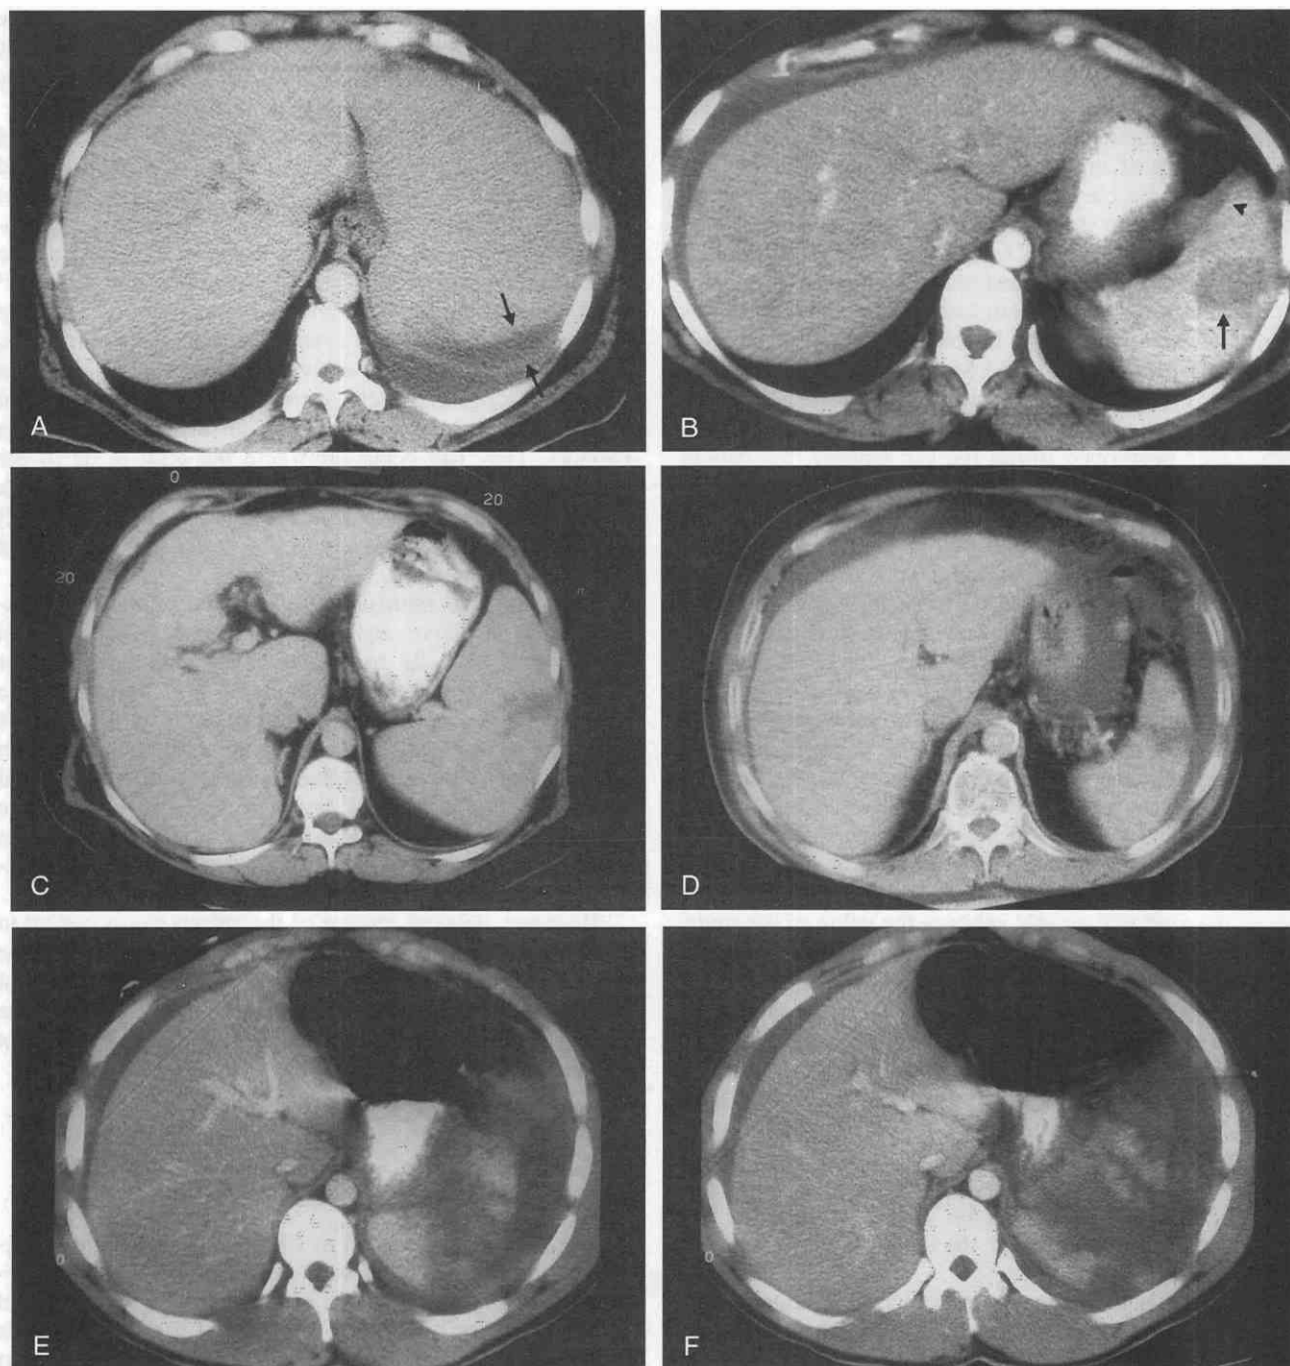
CT scans showing classification of trauma to the spleen. A, Grade I injury: A small subcapsular hematoma (arrows) can be seen in a patient with an enlarged spleen from chronic lymphocytic leukemia. There is also a left pleural effusion. B, Grade II injury: A 4-cm intraparenchymal hematoma (arrow) and a 30% subcapsular hematoma (arrowhead) are seen in a patient after a fall. C, Grade II injury: A 3-cm laceration without involvement of trabecular vessels is shown in the lateral aspect of the spleen. D, Grade III injury: There is a 4-cm laceration near the hilum. E, Grade IV injury: Hilar laceration with devascularization of approximately 50% of the spleen can be seen. F, Grade V injury: The spleen is shattered, and only minimal parenchyma remains.
